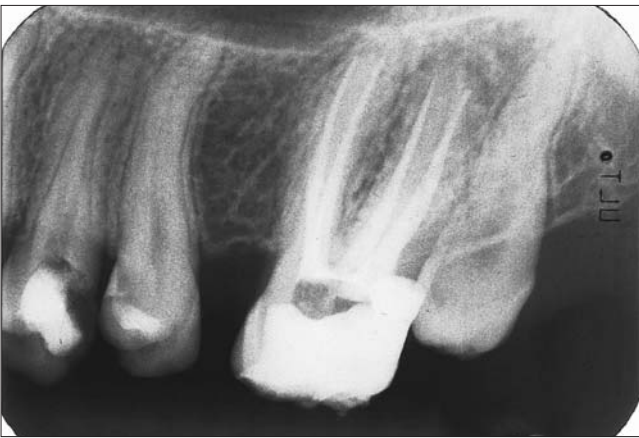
Postoperative radiograph showing the separation and divergence of the 4-rooted maxillary second molar.
